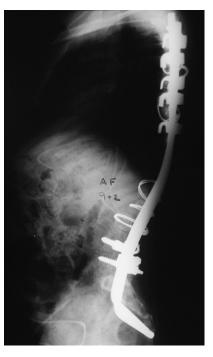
Postoperative radiograph of the child in Fig. 2. The paired rods are contoured to what is believed to be the maximum correction. They pass through the S1 neuroforamen and then angle laterally so that they abut the anterior aspect of the sacrum away from the midline structures. Such positioning allows one to apply significant corrective forces. Further stability is provided by lumbar pedicle screws and a cross-connector. Fixation cephalad to the bifid spine is obtained by sublaminar wires and laminar hooks. The youngster was reasonably mature at the time of the surgery, and a growth-preserving technique was not used.
